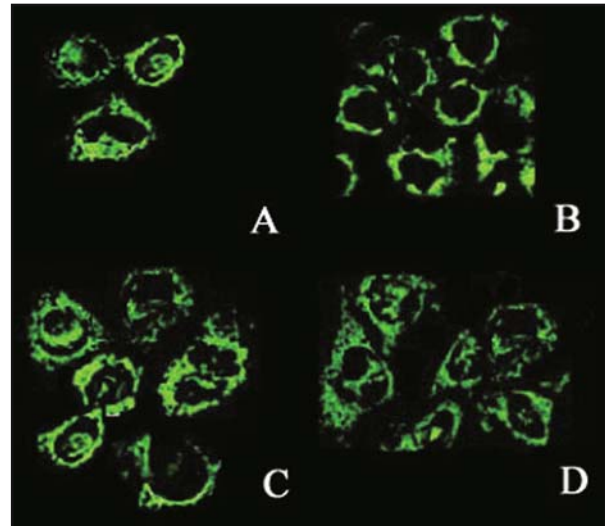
Intracellular DNR concentrations in cells treated with low intensity ultrasound. A, HepG₂/WT treated with DNR; B, HepG₂/ADM treated with DNR; C, HepG₂/ADM treated with US+DNR; D, HepG₂/ADM treated with VER + DNR.
